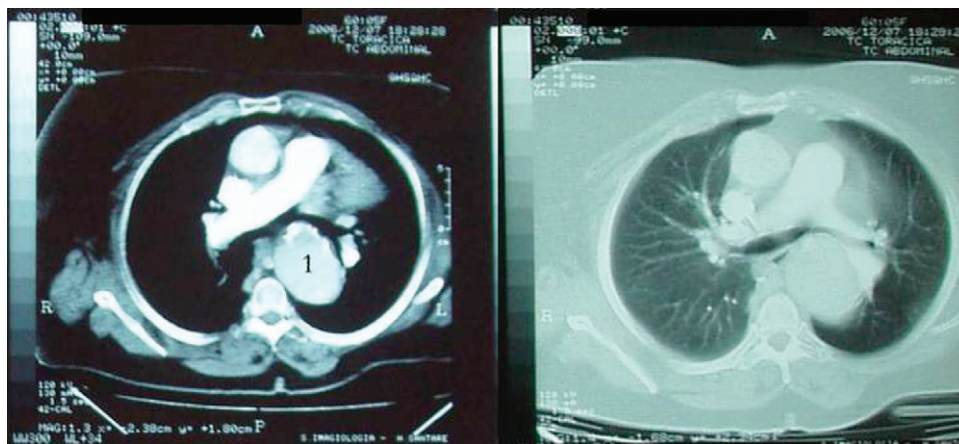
Computed tomography showing an aortic aneurysm (1).
